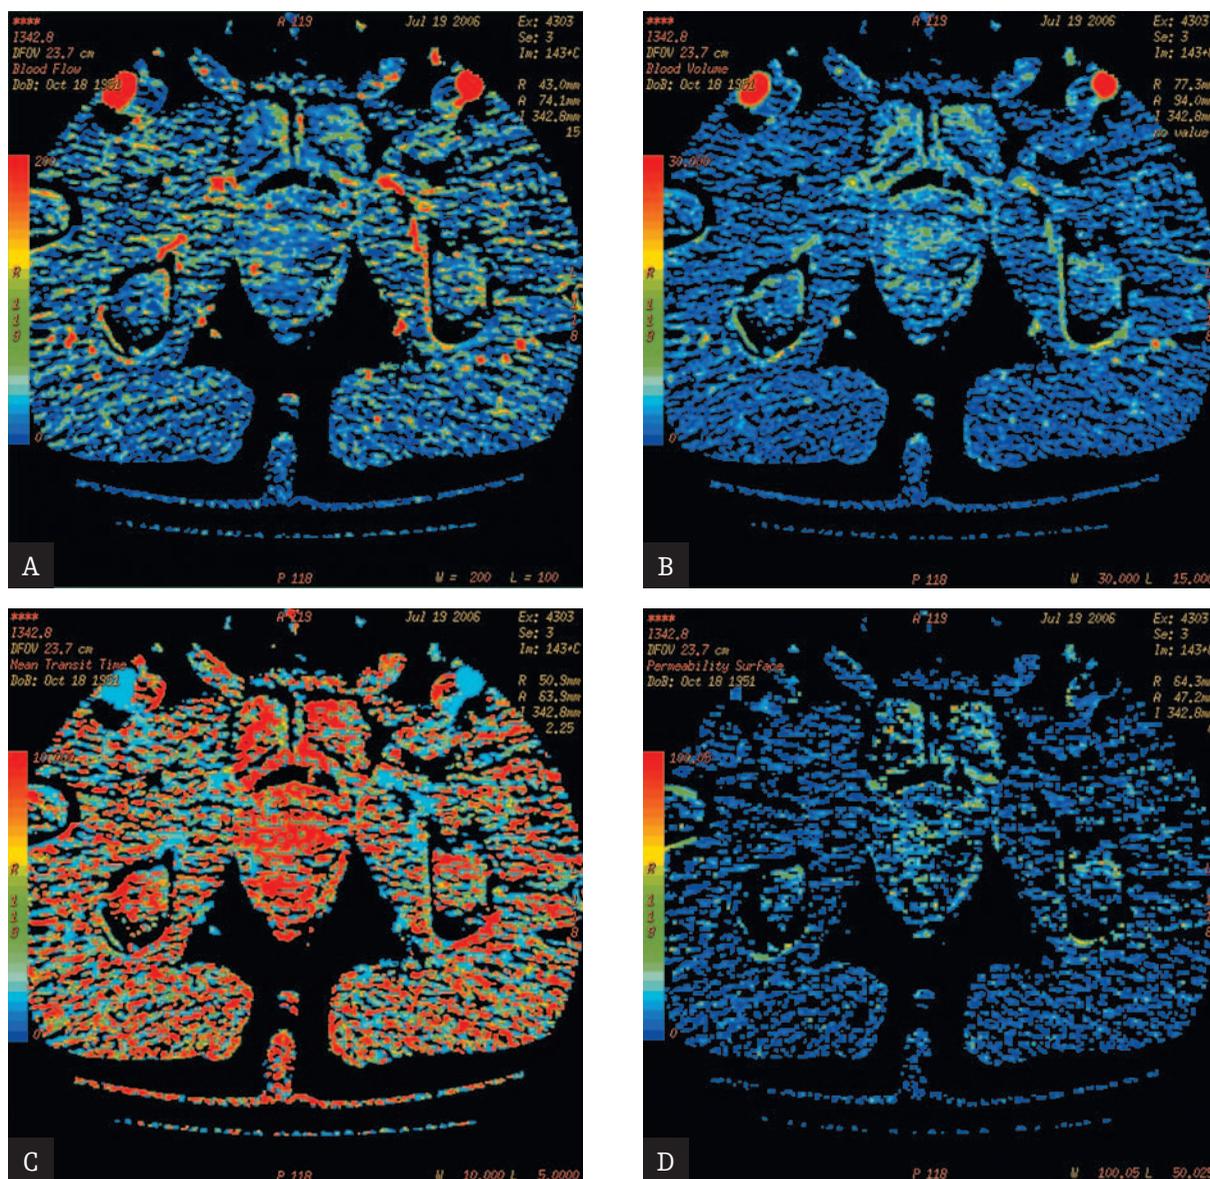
Prostate p-CT, parametrical maps of: A. Blood Flow, B. Blood Volume, C. Mean Transit Time, and D. Permeability Surface Focal pathological perfusion in the peripheral part of the right lobe.
